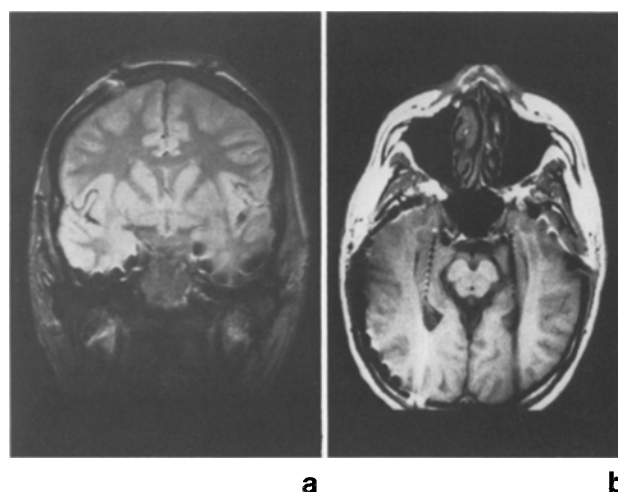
(a, b) Postoperative MRI-controls: exact placement of subtemporal strip electrodes (a) and of intrahippocampal depth electrodes (b)
